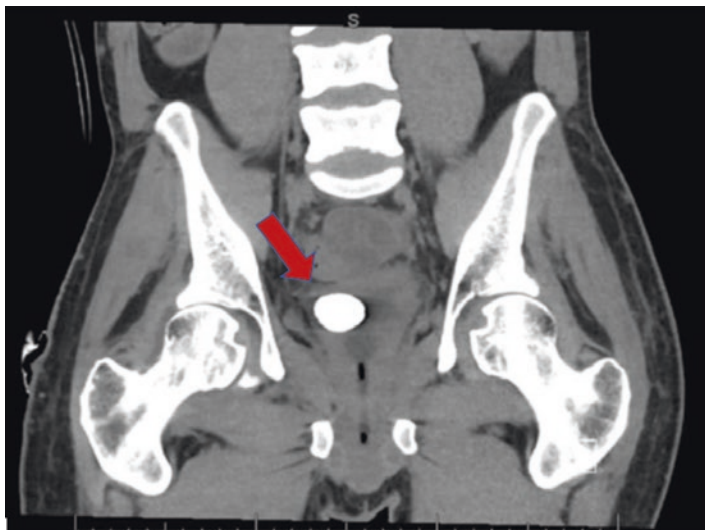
Non-contrast CT showing a patient with 2 cm bladder stone (indicated with red arrow). (Courtesy of University of Iowa, Department of Urology)
